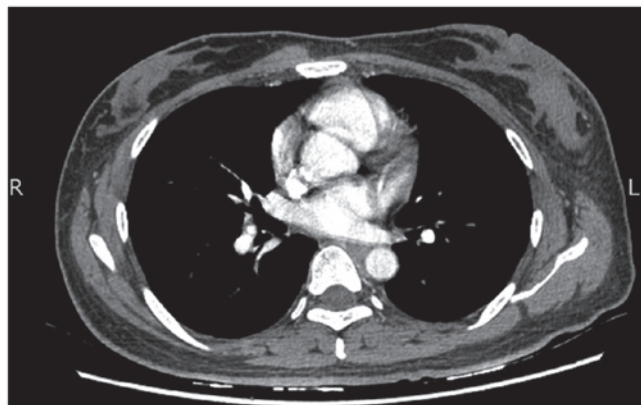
Chest computed tomography confirming swelling and thickening of the epidermis of the left breast. A number of small lymph nodes were identified in the left axilla.
